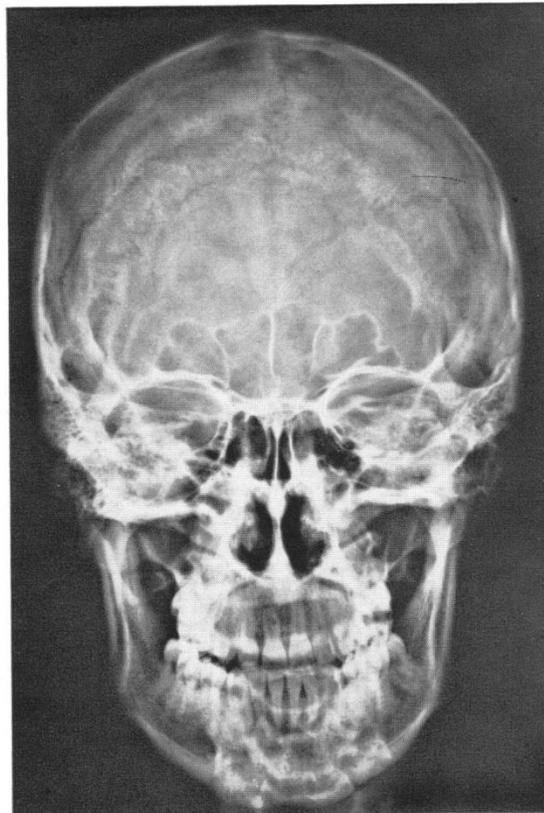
Straight posteroanterior view of skull: radiograph (Meschan & Ferrier-Meschan, 1968)
